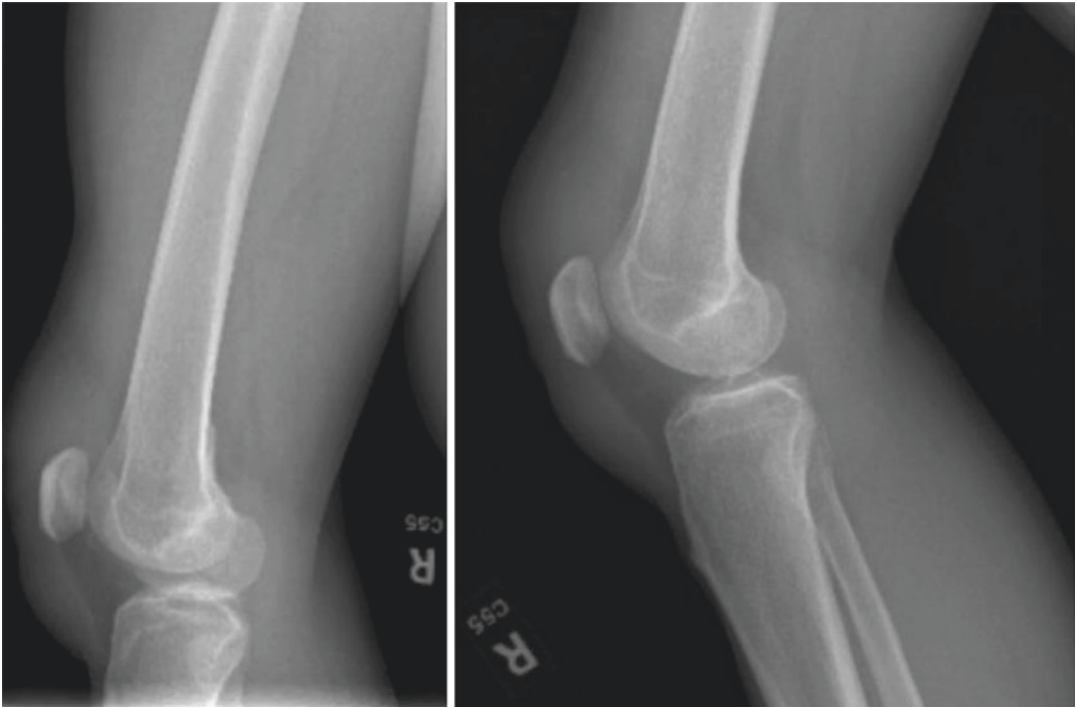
Initial X-ray, lateral
